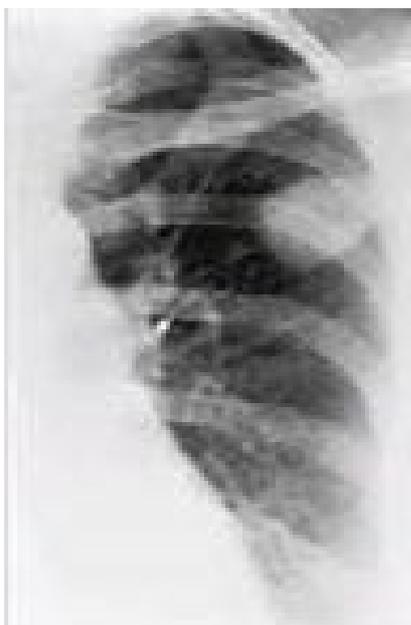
Chest x-ray showing smooth tuberculoma as persistent mass like opacities.
